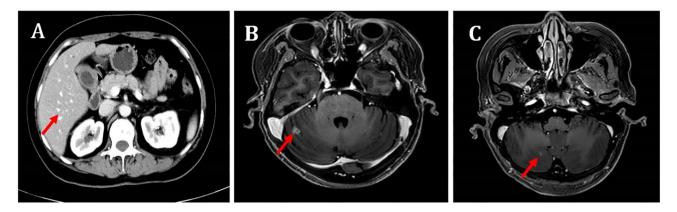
CT and MRI scans showing controlled liver lesions but progressive intracranial lesions. (A) CT scan showing a 5-mm liver lesion (persistent partial response). MRI scans of (B) 9-mm and (C) 2-mm brain lesions. CT, computed tomography; MRI, magnetic resonance imaging.
